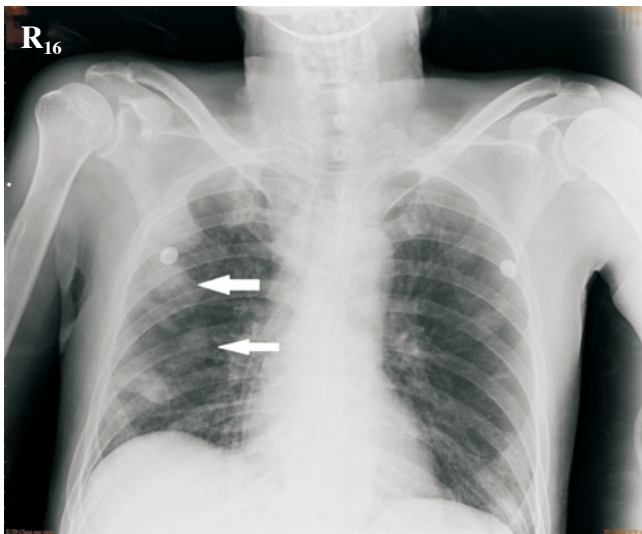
Radiograph of chest showing multiple hazy patches in the right lung indicating septic emboli in lungs.
